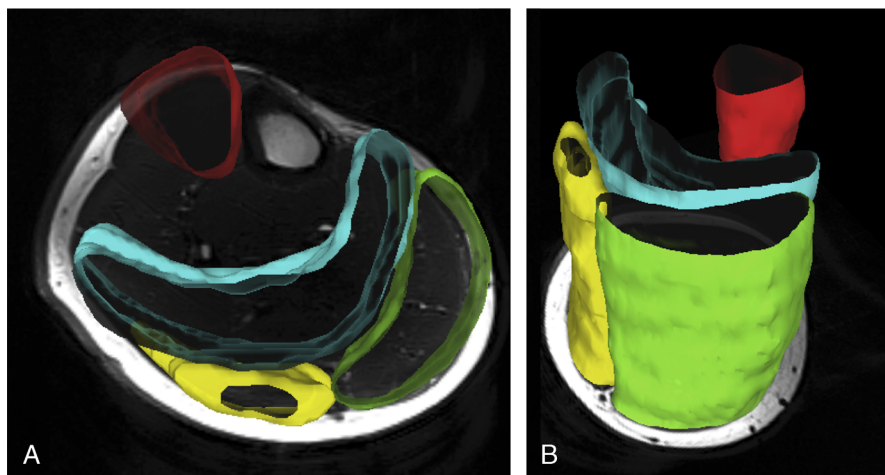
T2-weighted image of the calf muscle of 1 volunteer obtained at 7 T showing a 3-dimensional representation of the regions of interest of the 4 single investigated muscles (ie, red indicates tibialis anterior; green, gastrocnemius medialis; yellow, gastrocnemius lateralis; blue, soleus) from the axial (A) and oblique coronal (B) perspectives.
